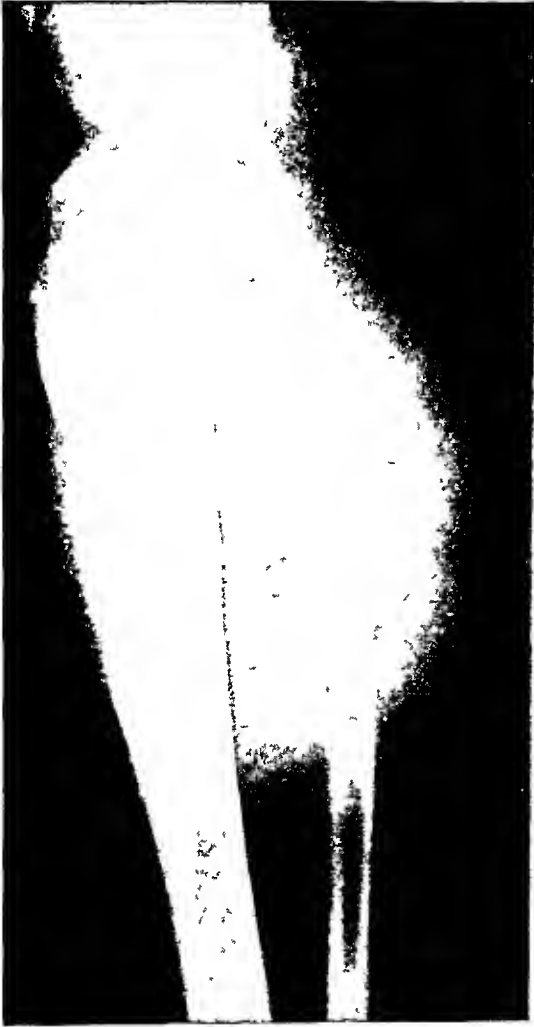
Roentgenogram showing the large soft-tissue mass and destruction of the upper end of the fibula.
